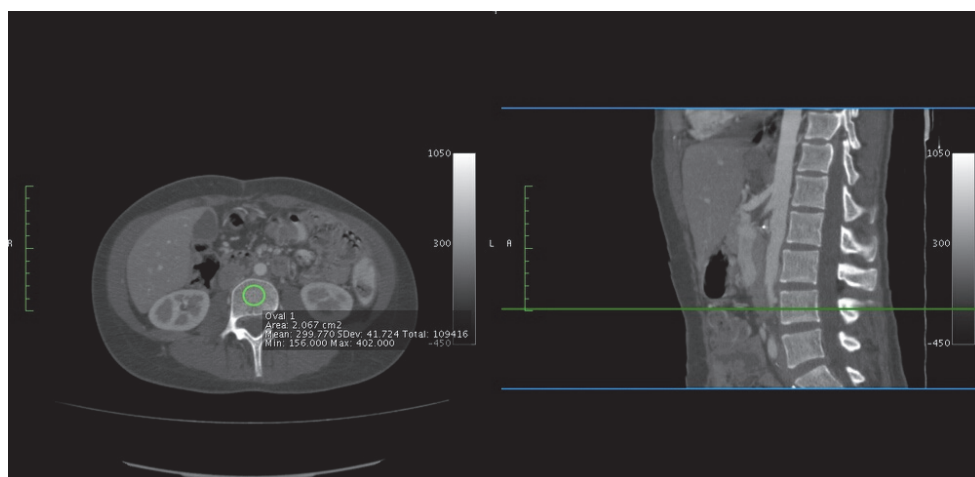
Axial L3 vertebral CT slice of 20-year old woman shows nonosteoporotic L3 vertebral bone density measurement in Hounsfield Unit (mean: 299 HU).
